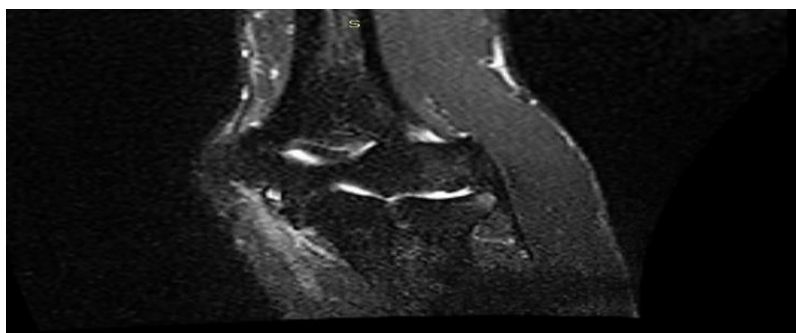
Coronal T2 fat-suppressed MR image of the right elbow demonstrating mild hyperintense signal and diffuse thickening along the course of the ulnar nerve in the cubital-tunnel region, consistent with inflammatory neuritis.
